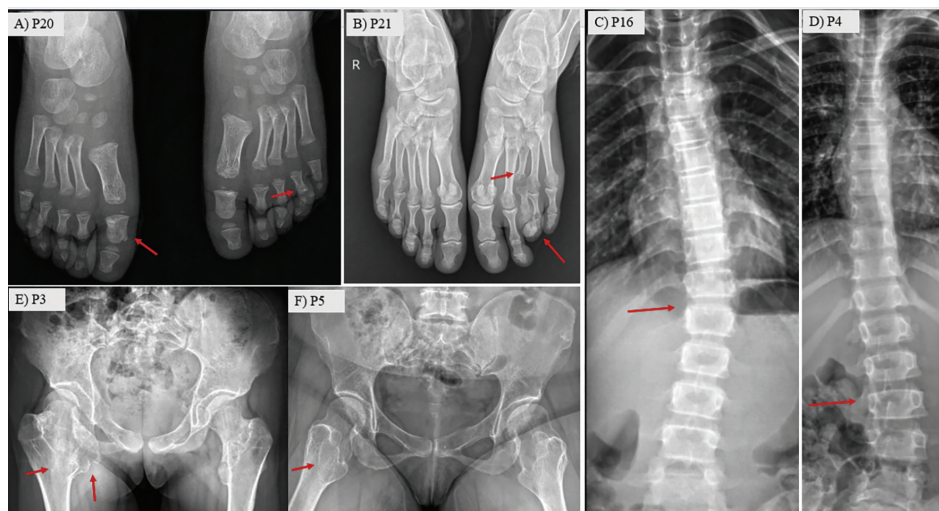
Findings observed in the feet, pelvis/proximal femur, and spine in patients with hereditary multiple exostoses. Red arrows indicate the relevant pathology. A) P20: Exostosis/osteochondroma foci in the foot at the metatarsal and phalangeal levels. B) P21: Multiple exostoses in the foot involving the metatarsals and phalanges. C) P16: Scoliosis on spine radiograph (arrows indicate the curvature). D) P4: Scoliosis on spine radiograph (arrows indicate the curvature). E) P3: Exostosis/osteochondroma foci around the proximal femur/hip on pelvic radiograph. F) P5: Exostosis/osteochondroma foci around the proximal femur/hip on pelvic radiograph
